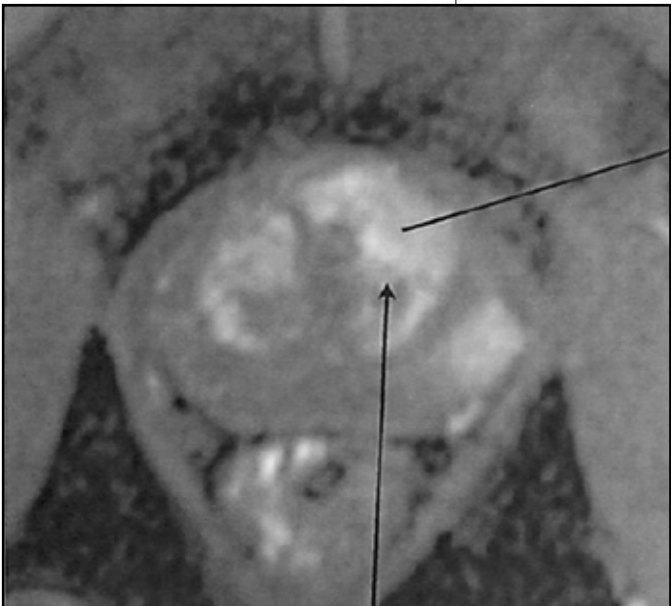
MRI image of prostate tumour prior to NanoKnife therapy. The cancer is an anterior tumour seen on MRI Diffusion weighted imaging. Arrow points to tumour
